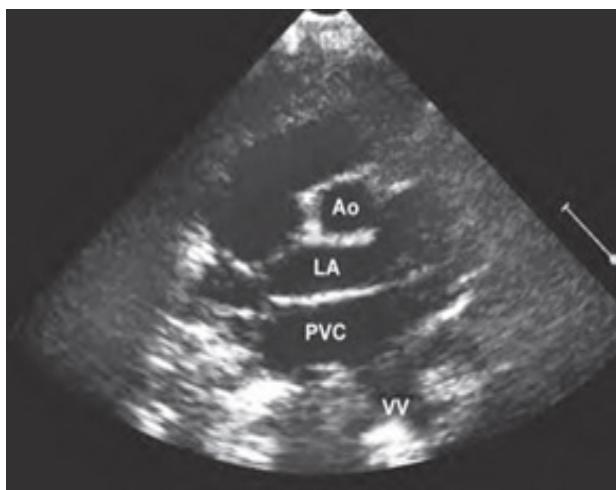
Parasternal long axis view on echocardiography showing all pulmonary veins forming a common confluence behind LA.
